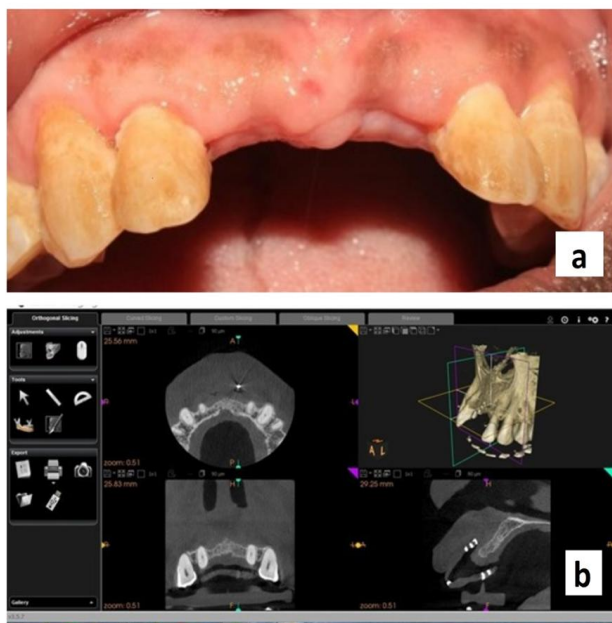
(a) Postoperative clinical view at 3 months, (b) postoperative CBCT at 3 months
